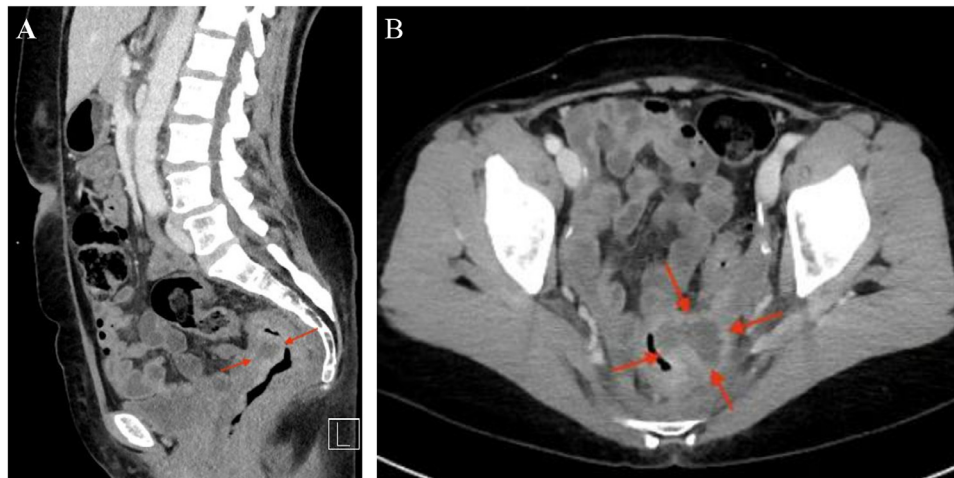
(A) CT scan abdomen and pelvis (A: sagittal view, B: axial view) showing suspected mural abscess (red arrows) and significant stool burden consistent with constipation.
